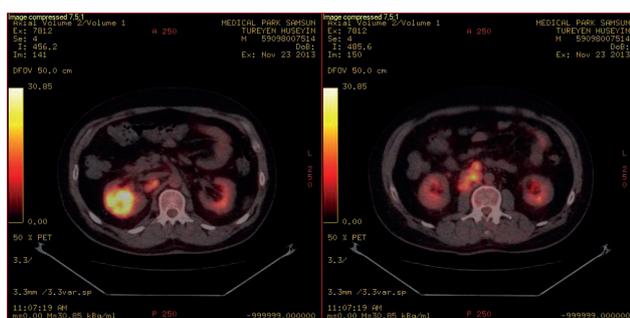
a,b: Axial PET CT images showed the right renal tumor and the regional conglomerated lymphadenopathies showing high SUVmax values representing malignancy.
